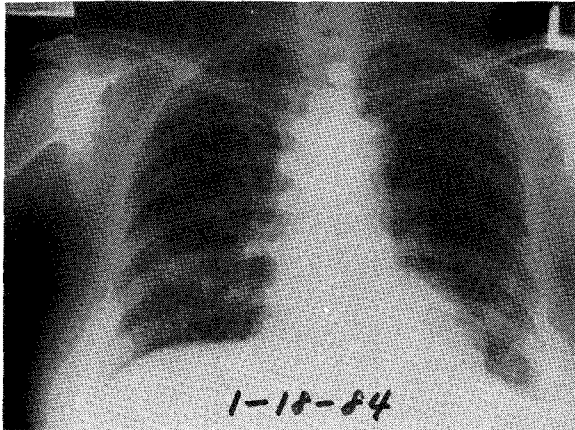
Post-radiation X-rays of case 2 shows marked regression of metastatic nodules.
